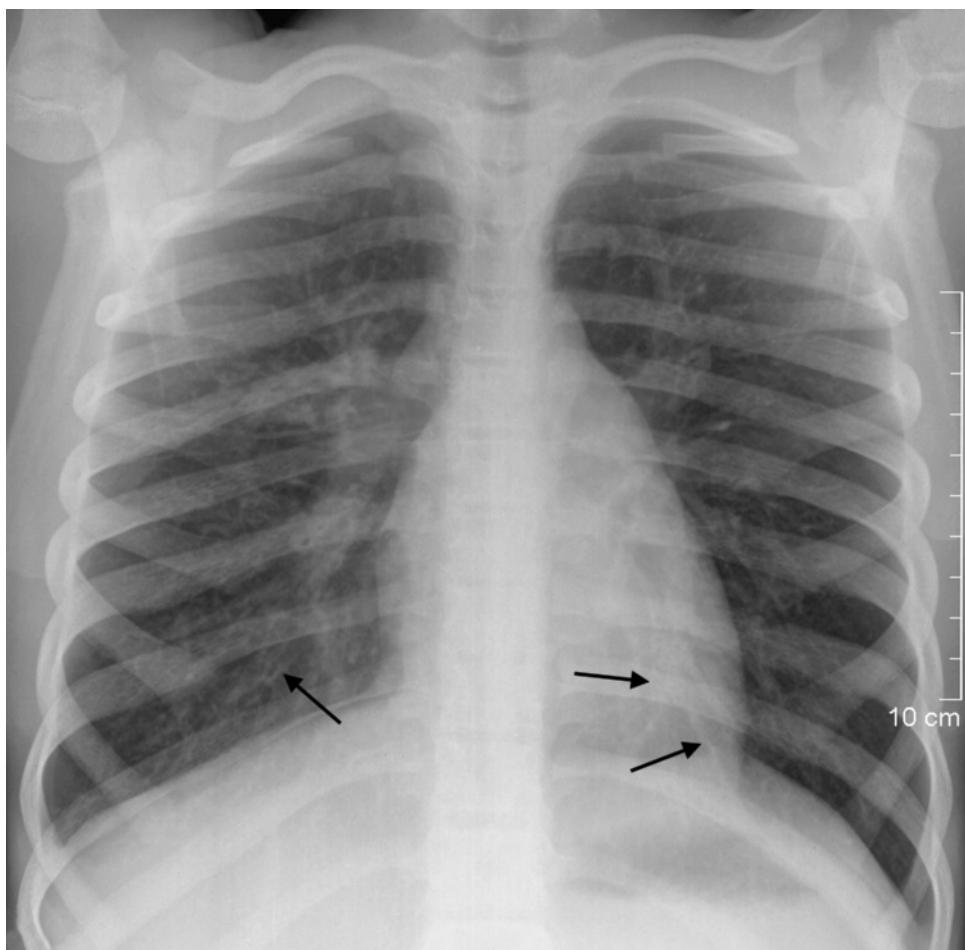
Cystic fibrosis. The patient is an 8-year-old boy with cystic fibrosis; follow-up radiograph in *Pseudomonas* pneumonia. Significant hyperinflation in the peripheral chest with primarily central peribronchial shadowing and diffuse nodular pattern of opacities. Dilated bronchi are presumably present in both lower lobes (black arrows). Residual infiltrate in the right perihilar region.
